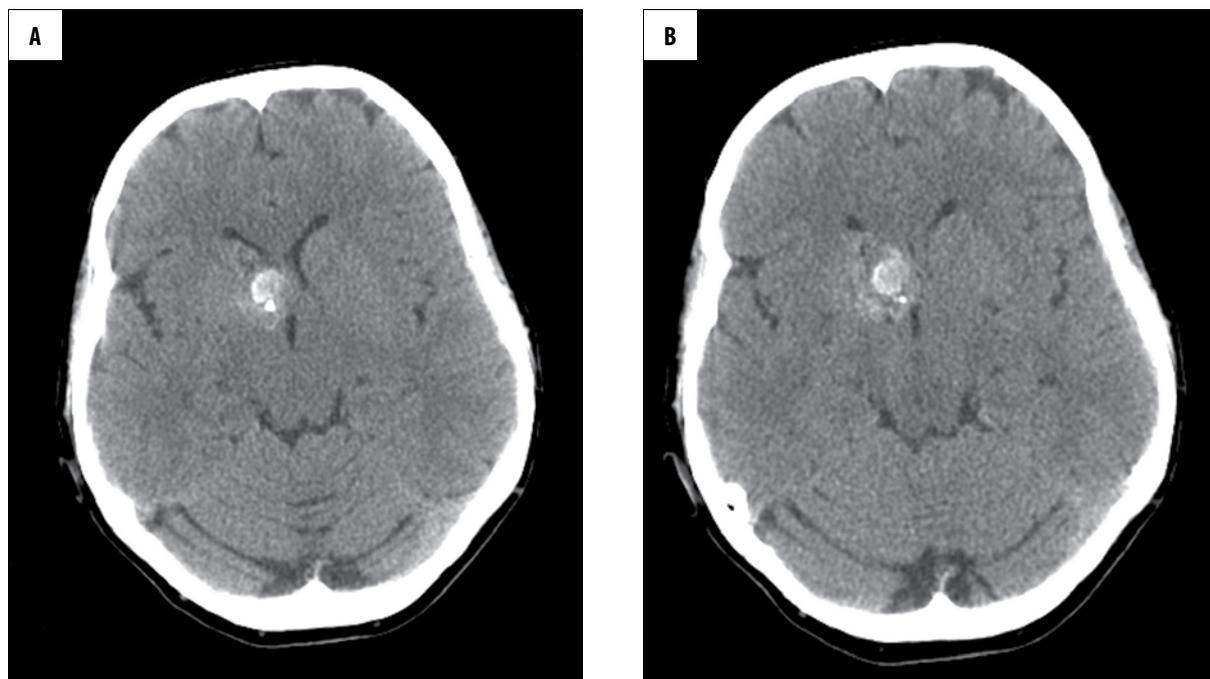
(A, B) Head CT, native scan – irregular hyperdense focus with calcifications and mass effect located in the right brain hemisphere, adjacent to the third ventricle and lower part of lateral ventricle frontal horn.
